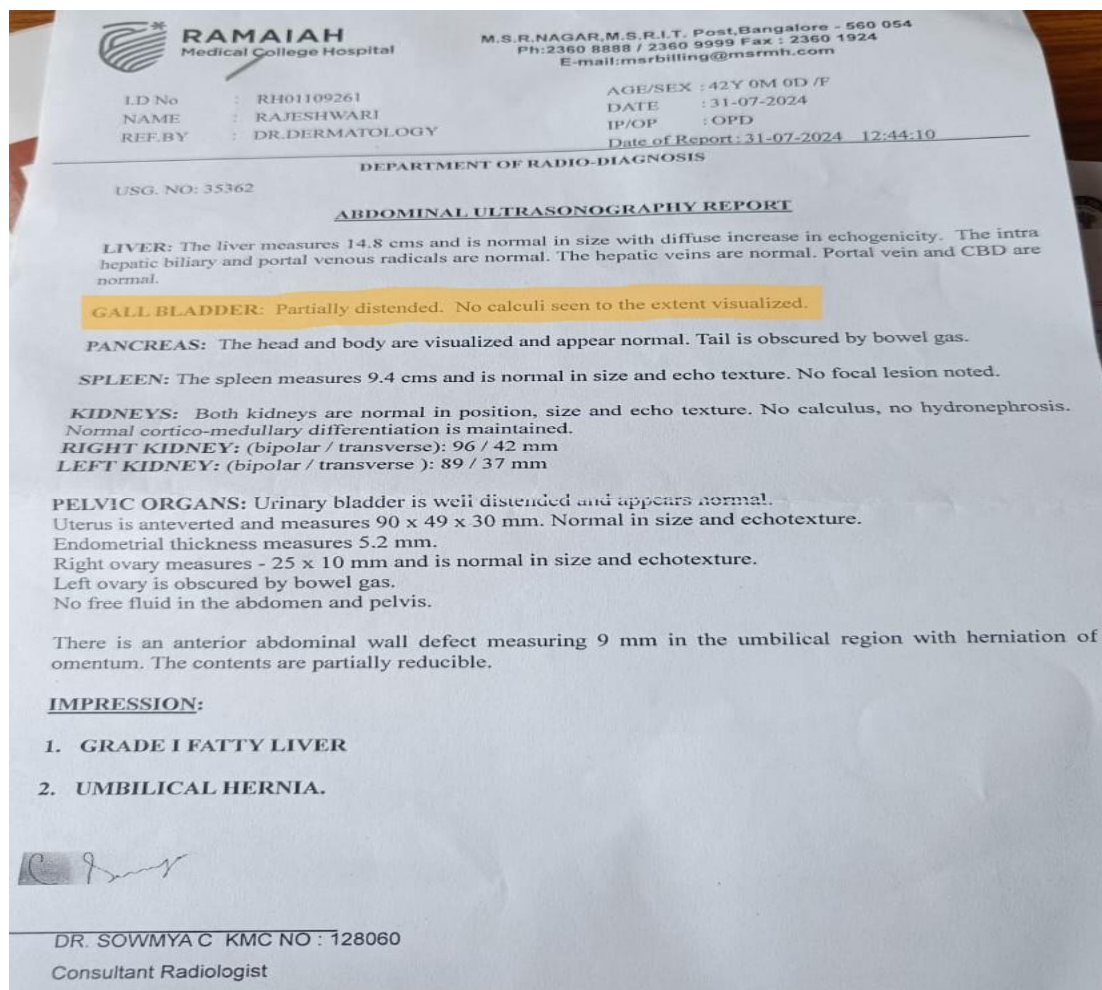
Ultrasound image showing the dis-appearance of gallstones after homeopathic treatment.
